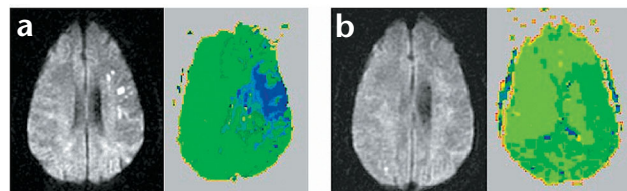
Case 1's DWI (left) and PWI (right) scans before and after intervention to restore blood flow. (a) Scans done when written naming of verbs was impaired. (b) Scans after intervention, when written naming of verbs had recovered.
